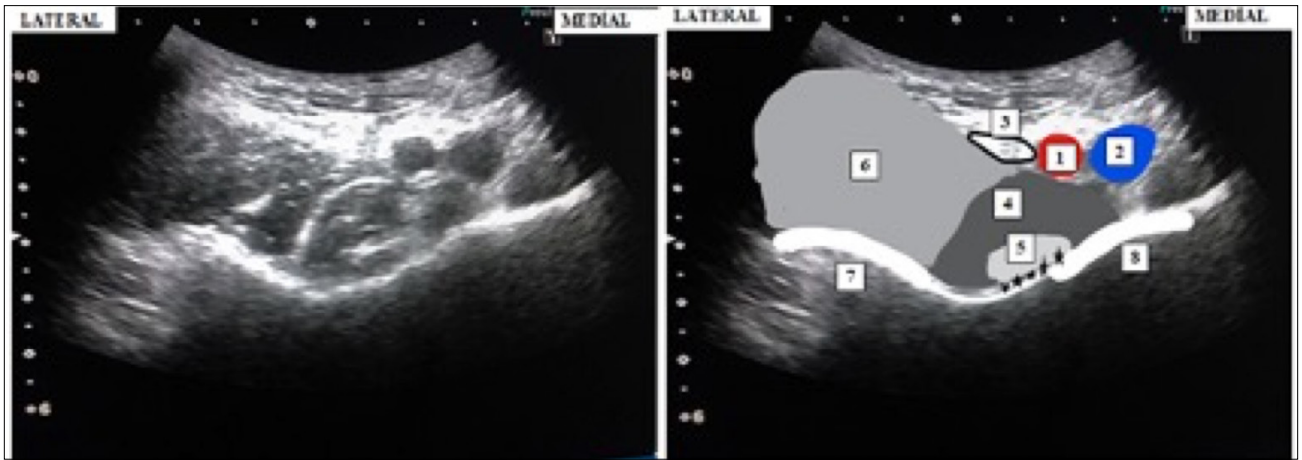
Application of the pericapsular nerve group (PENG) block under ultrasound guidance, femoral artery. 2: Femoral vein; 3: Femoral nerve; 4: Psoas muscle; 5: Psoas tendon; 6: Iliac muscle; 7: Spina iliaca antero-inferior; 8: Iliopubic eminence; *: Area where the local anesthetic agent is administered.
